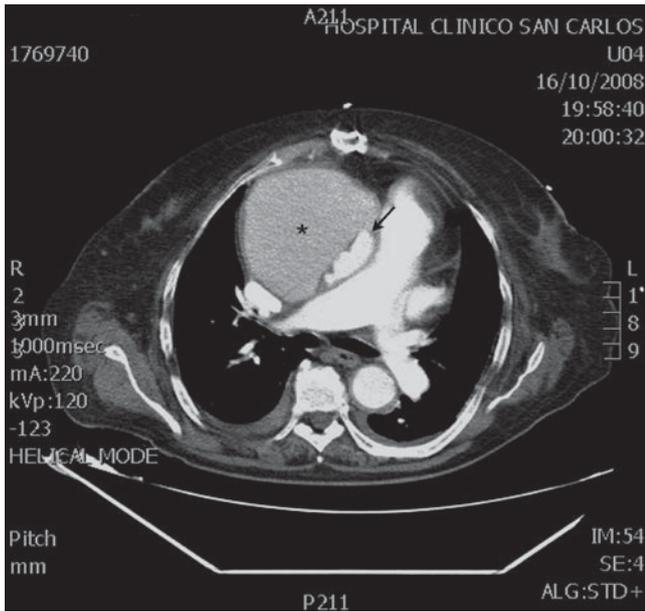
Post-operative CT scan in a patient operated on 10 months earlier because of type A aortic dissection. Surgery consisted of the ascending aorta resection including the intimal tear and a graft interposition of the ascending aorta and hemiarch, with preservation of the native aortic valve. The axial image discloses a pseudoaneurysm (asterisk), which is filled by iodine contrast. The big mass compresses the graft and collapses it (arrow)
